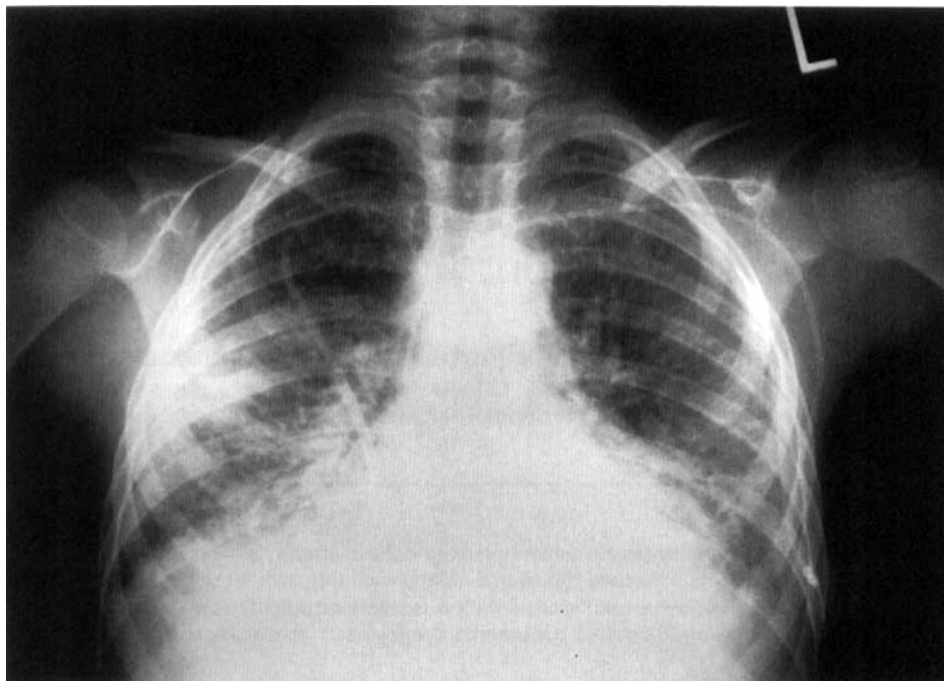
Chest radiograph at presentation. Radiograph from date of admission. Note diffuse interstitial infiltrates throughout both lungs.
